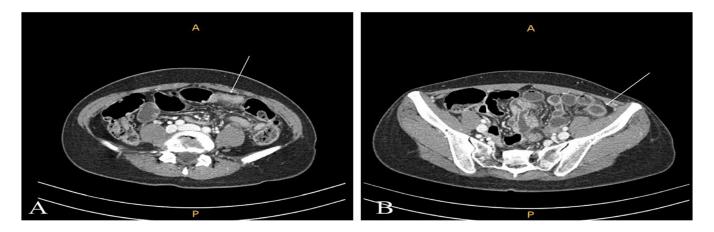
Abdominal computed tomography showing. (A) a hernia and (B) congestion and swelling of the small intestine.
